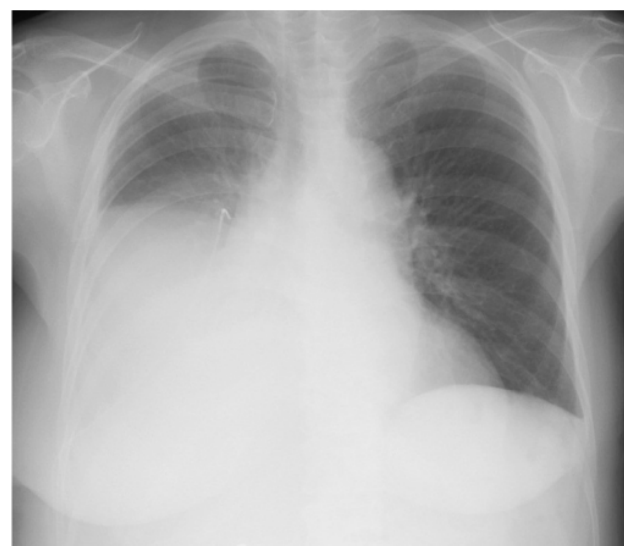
Chest radiography showing an improved right-sided pleural effusion after surgery.
